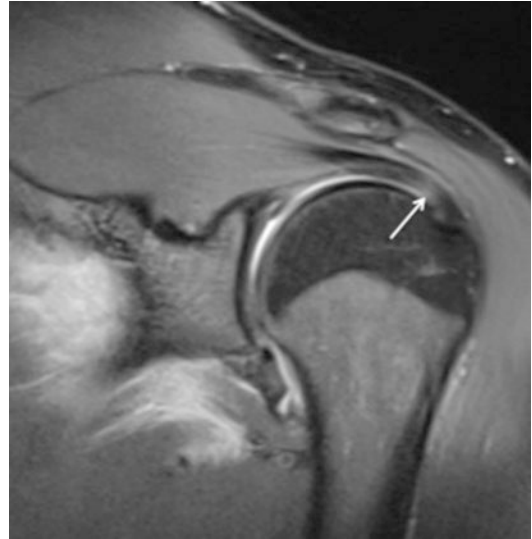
Coronal MRI demonstrating a partial-thickness articular-sided rotator cuff tear in a throwing athlete (arrow)
